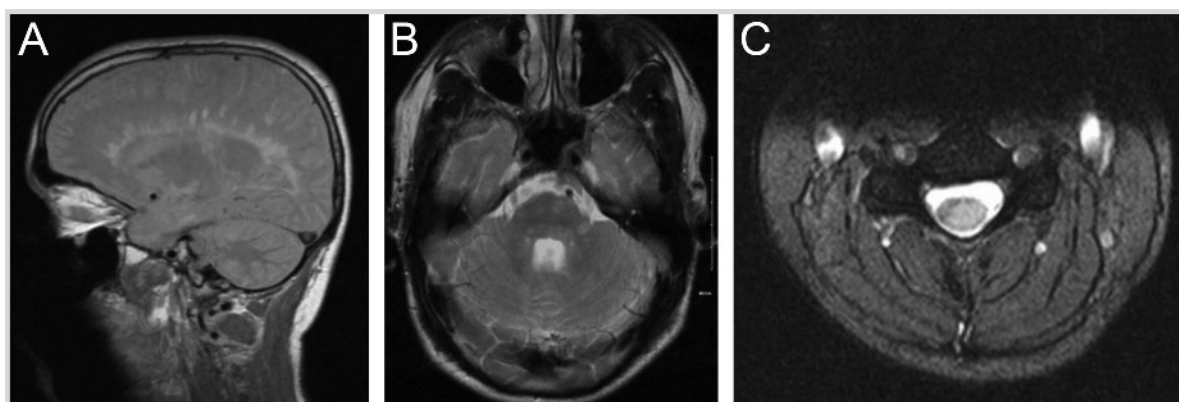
A high T2 lesion burden. *A*, Sagittal T2 brain MRI showing typical Dawson fingers and corpus callosum involvement; *B*, axial T2 brain MRI revealing multiple infratentorial lesions; *C*, axial T2 cervical spinal cord MRI with a large lesion involving most of the cord width.
